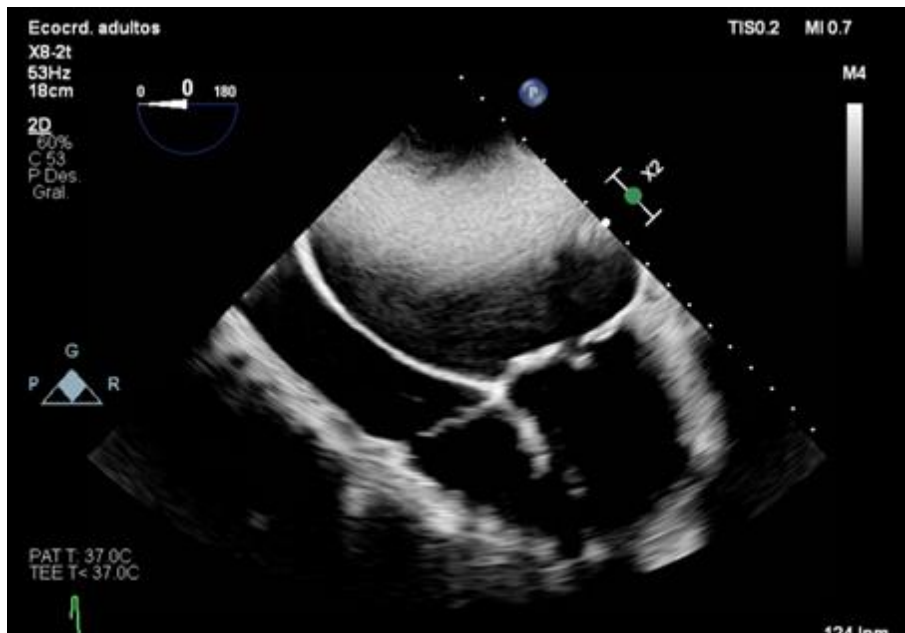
Transesophageal echocardiogram showing a markedly dilated left atrium as well as an extremely dilated right atria that distorted the normal anatomy with increased difficulty obtaining the planes to evaluate the heart
